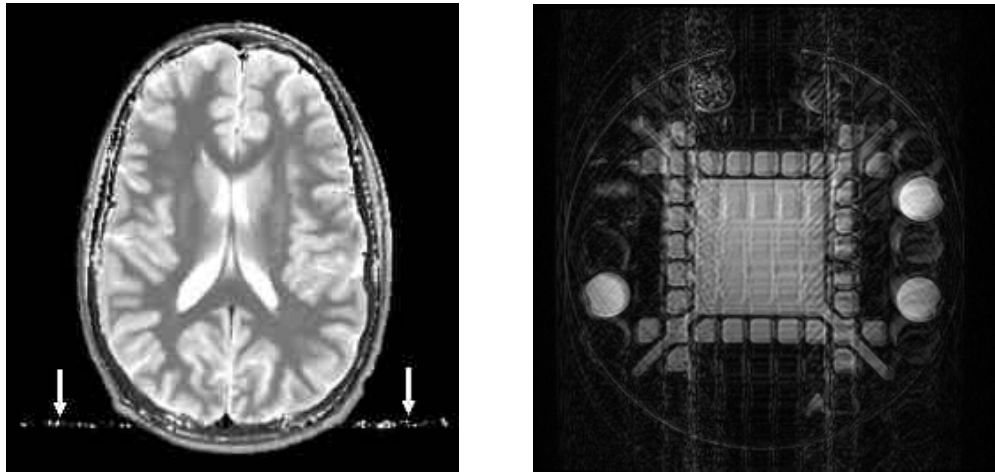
Example of MRI Artifacts
